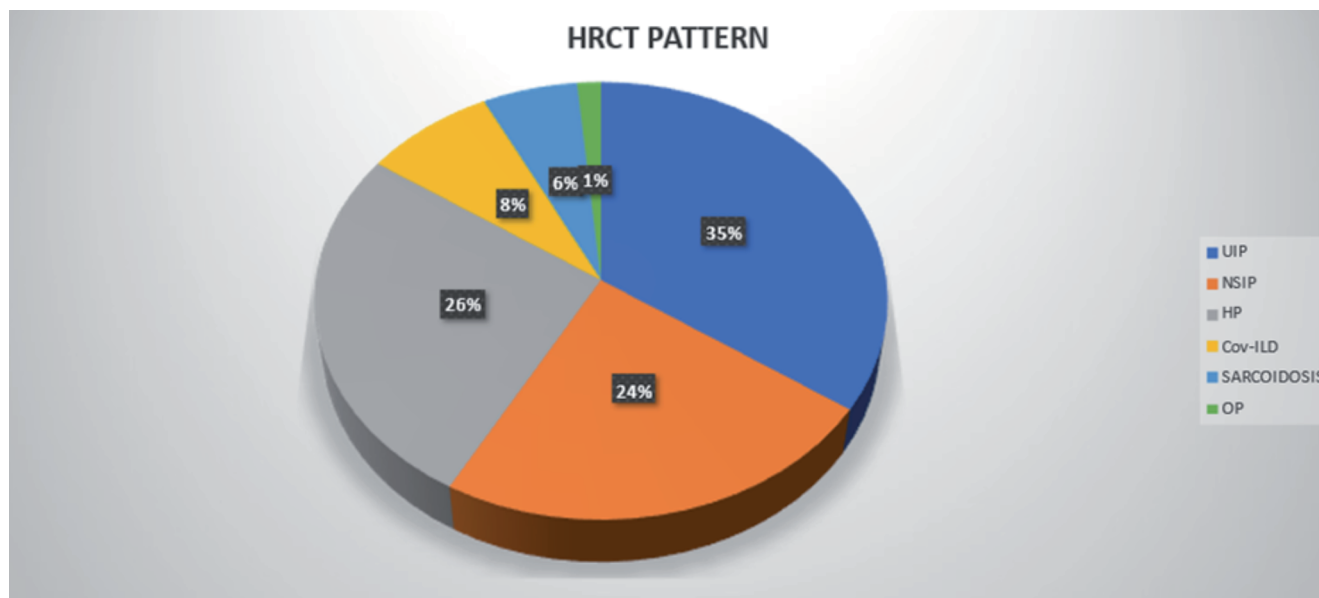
High-resolution computed tomography pattern of the interstitial lung disease cases in the post-COVID era. UIP, usual interstitial pneumonia; NSIP, non-specific interstitial pneumonia; HP, hypersensitivity pneumonitis; ILD, interstitial lung disease; OP, organizing pneumonia.
